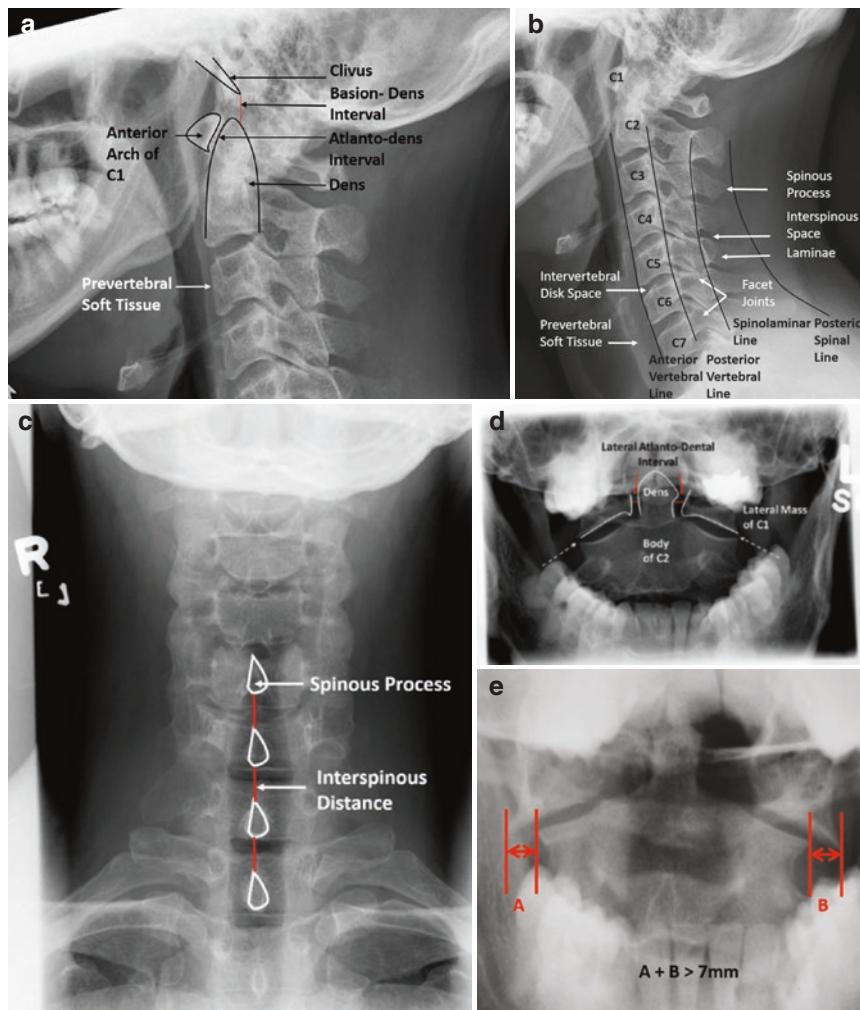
(a) Lateral view on cervical radiograph, showing the upper cervical anatomy: (1) The tip of the clivus (basion) should point to the dens, and the distance between the basion and the tip of the dens (basion-dens interval) should be less than 12 mm; (2) the distance from the anterior arch of C1 to the anterior aspect of the dens (atlanto-dens interval) should be less than 3 mm; and (3) the prevertebral soft tissue should be less than 7 mm anterior to C1–C3 (i.e., less than 50% width of the C2 vertebral body). The contour of the prevertebral soft tissue should generally follow the contour of the vertebrae: it should be slightly convex anteriorly to the anterior arch of C1 and take on a concave shape posteriorly. However, endotracheal tube reduces aeration to the nasopharynx and can make visualization of the prevertebral soft tissues difficult. (b) Lateral view on cervical radiograph, showing lower cervical spine anatomy: (1) the anterior vertebral, posterior vertebral, spinolaminar, and spinous process lines should be smooth and free of abrupt discontinuity; (2) the intervertebral disc spaces should be approximately equal in size; (3) the facet joints should be smooth and regular; (4) the interspinous spaces should be equal in size at all levels; and (5) the width of the prevertebral soft tissue should be
